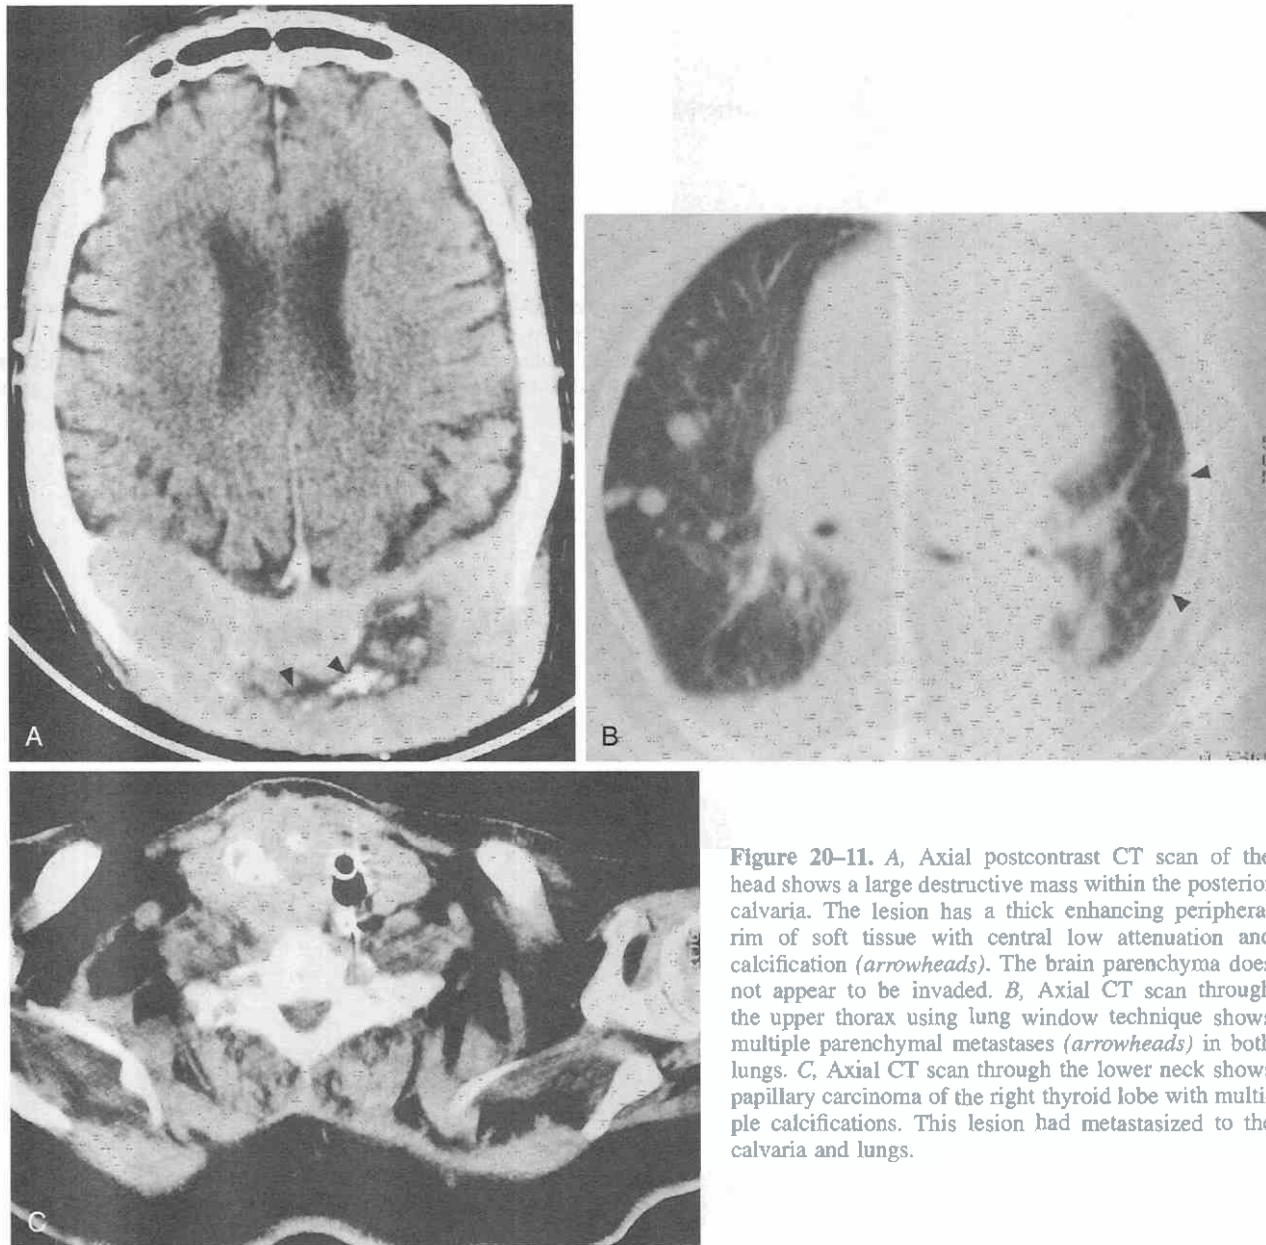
A, Axial postcontrast CT scan of the head shows a large destructive mass within the posterior calvaria. The lesion has a thick enhancing peripheral rim of soft tissue with central low attenuation and calcification (arrowheads). The brain parenchyma does not appear to be invaded. B, Axial CT scan through the upper thorax using lung window technique shows multiple parenchymal metastases (arrowheads) in both lungs. C, Axial CT scan through the lower neck shows papillary carcinoma of the right thyroid lobe with multiple calcifications. This lesion had metastasized to the calvaria and lungs.
